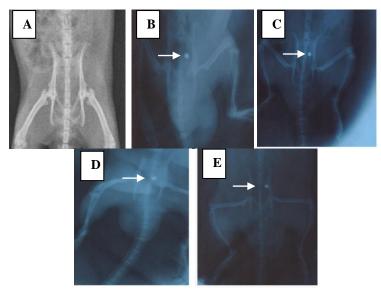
X-ray images of antiurolithic activity of *B. trifoliata* extract. (a) vehicle-treated control, (b) Experimental Control (only zinc disc implanted), (c) zinc disc implanted and treatment 50 mg/kg p.o., (d) zinc disc implanted and treatment 100 mg/kg p.o., (e) zinc disc implanted and treatment 150 mg/kg p.o.
